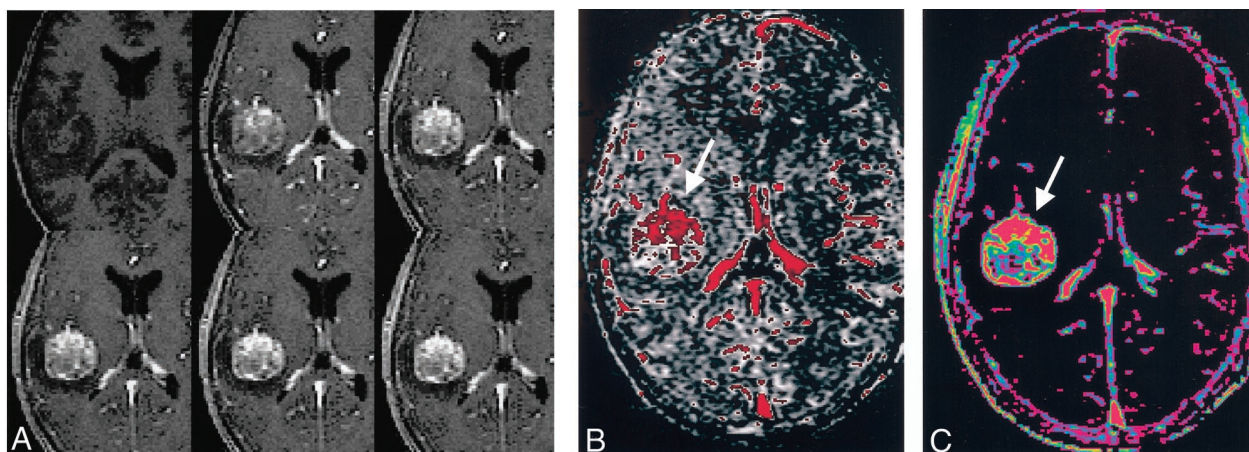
A, Representative images from the dynamic contrast-enhanced MR study in the patient in Figure 2. As seen on the CT scans (Fig 2), contrast enhancement is strong and immediate, and wash-out is slow. After the injection of contrast agent, the tumor is immediately and strongly enhancing (top row, middle and right images), and it remains hyperintense relative to the vascular signal intensity (bottom row).
